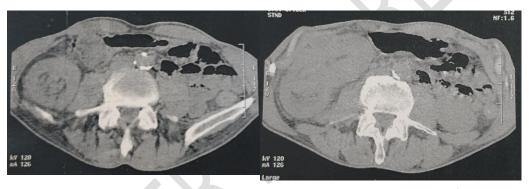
the abdominal CT scan showed an ileocolic invagination with circumferential thickening of the the ascending colon and transverse colon.
